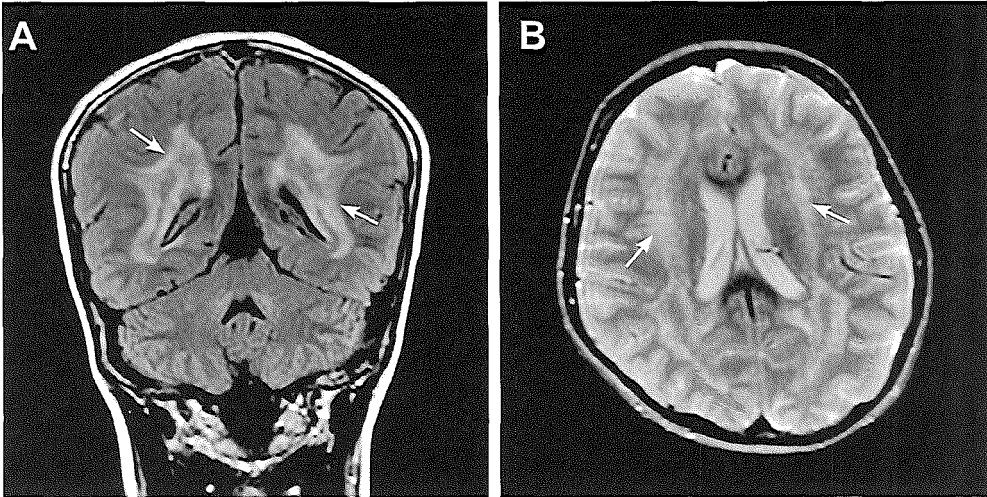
Brain MRI scan of patient 1 at the age of 9 years.
